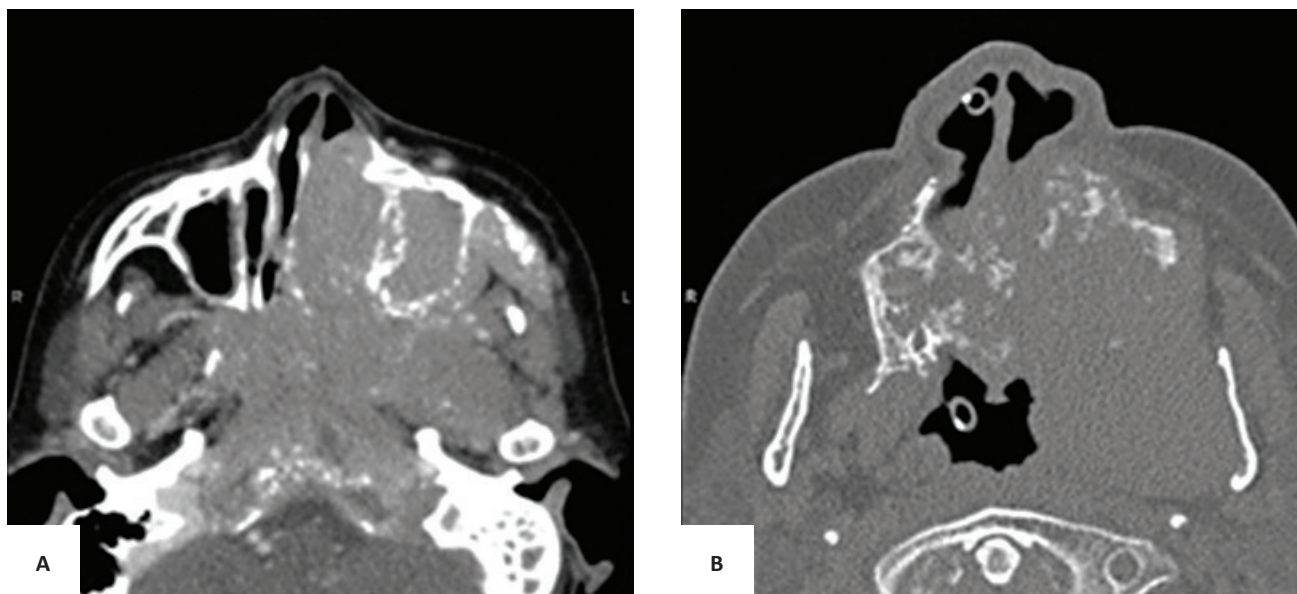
Paranasal Sinus CT Scan after contrast. (A) PNS Axial plane. (B) FESS Axial plane. A large enhancing irregular soft tissue mass lesion (9.7x7.8x5.9 cm) is seen in the left maxillary region extending into the left nasal cavity, left masticator space, left buccal mucosa, both sides of the hard palate, left soft palate, both sides of the nasopharyngeal roof, clivus, both sphenoid sinuses and left posterior ethmoid sinus.
